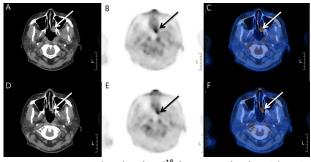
Images of CT (A,D), 2-[¹⁸F] FDG PET (B,E) and fused PET/CT (C,F) of the nasal cavity demonstrated a mild hypermetabolic soft tissue lesion (SUVmax 3.9, solid arrow).
